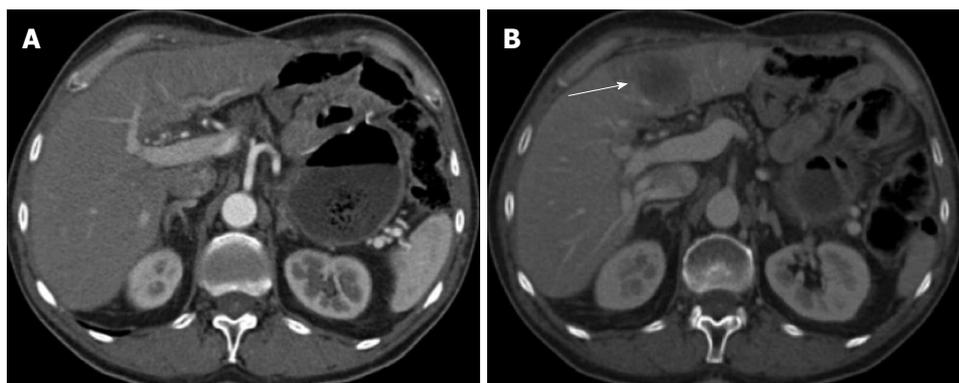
Axial computed tomography scan after *iv* iodinated contrast medium administration in the arterial hepatic phase (A) and portal phase (B). A: The computed tomography study does not show focal lesions in the liver parenchyma (Jul 2008); B: A focal nodular hypoattenuated lesion is present affecting the left hepatic lobe (arrow); it presents with regular margins and appears mildly vascularised (Nov 2008).
